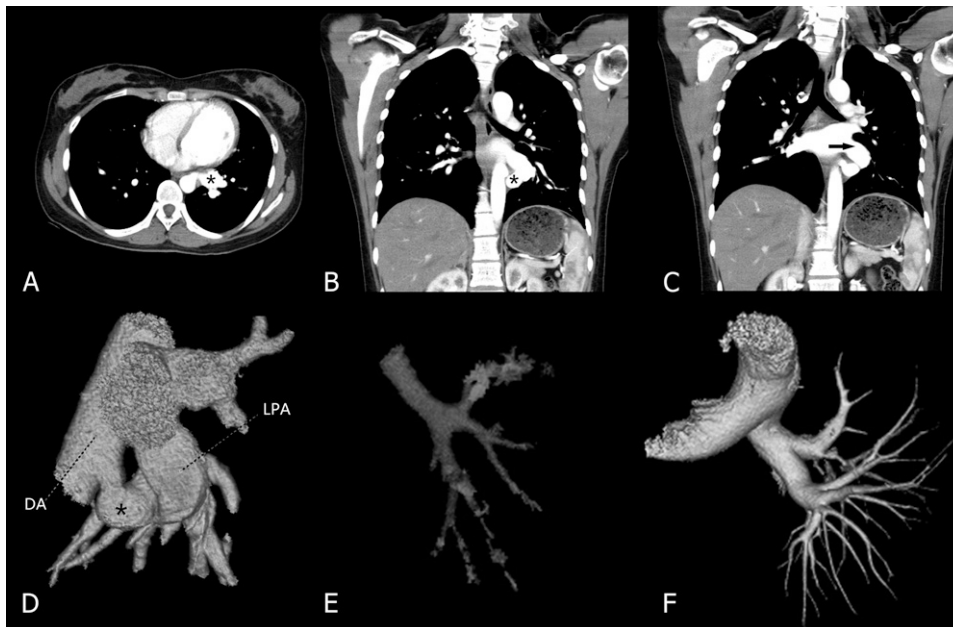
Contrast-enhanced CT scan shows the anatomic structure of DAPVF, the left bronchial tree, and left pulmonary branches. A, The anomalous systemic artery (*) arises from the descending aorta. B, The anomalous systemic artery (*) is connected with the left inferior pulmonary vein. C, The dilated inferior pulmonary vein (black arrow) joins the left atrium. D, Three-dimensional reconstruction of DAPVF. The narrowest inner diameter of DAPVF is 9 mm. E, The normal left bronchial tree. F, The normal left pulmonary arterial branches. DA = descending aorta; DAPVF = descending aorta-pulmonary vein fistula; LPA = left pulmonary artery.
